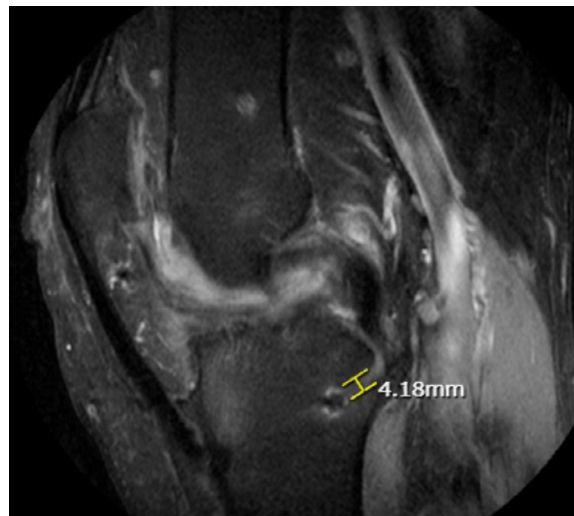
Magnetic resonance imaging (MRI) evaluation of tunnel widening by comparing MRI tunnel size to diameter of original drill used to drill tunnel. The dotted white line indicates the funnel-shaped morphology of the enlarged tunnel.
